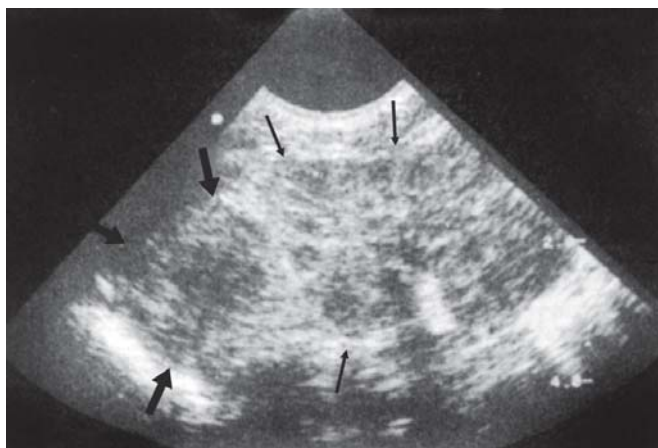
Ultrasound of abdomen.* Note the right adrenal hemorrhage (thick arrows) and displacement of the right kidney downward (thin arrows)
